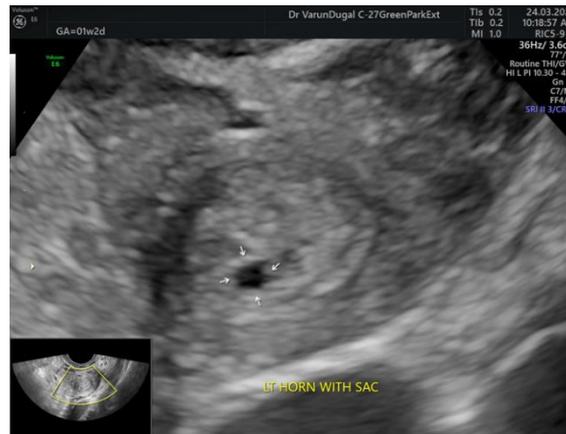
Showing ultrasound image of left uterine horn with sac.
